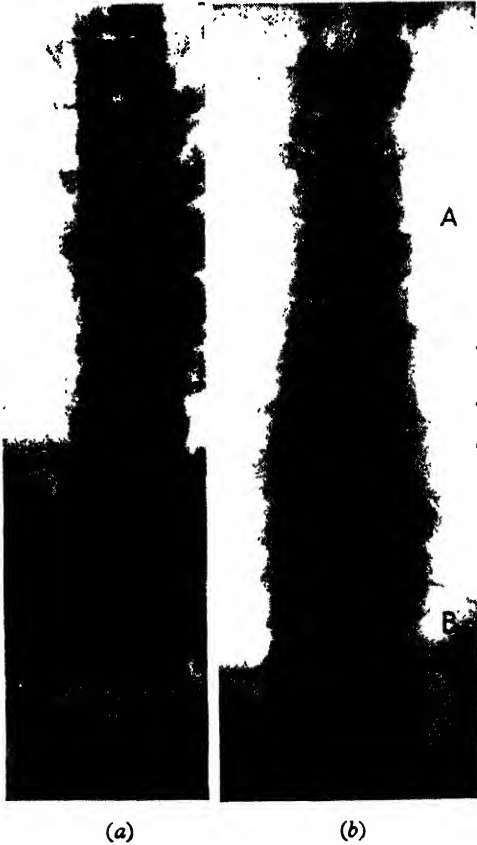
(a) Anteroposterior X-ray of spine showing normal pedicles. (b) Destruction of pedicles between sites A and B by pressure of a long fusiform intramedullary tumour.
